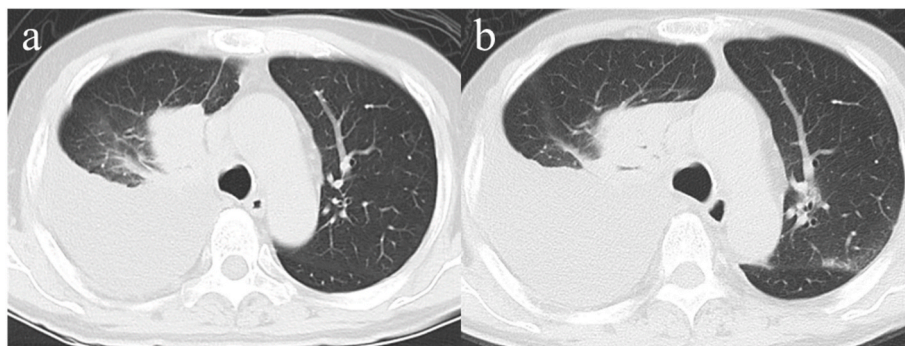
Computed tomography. a: before treatment of immune checkpoint inhibitor, b: on admission.
